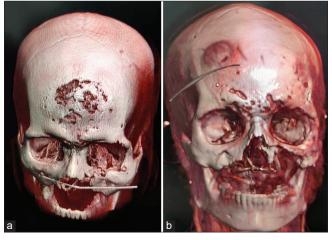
(a and b) 3D computed tomography scan images showing frontal bone osteomyelitis as a sequela of rhinocerebral mucormycosis (RCM).
